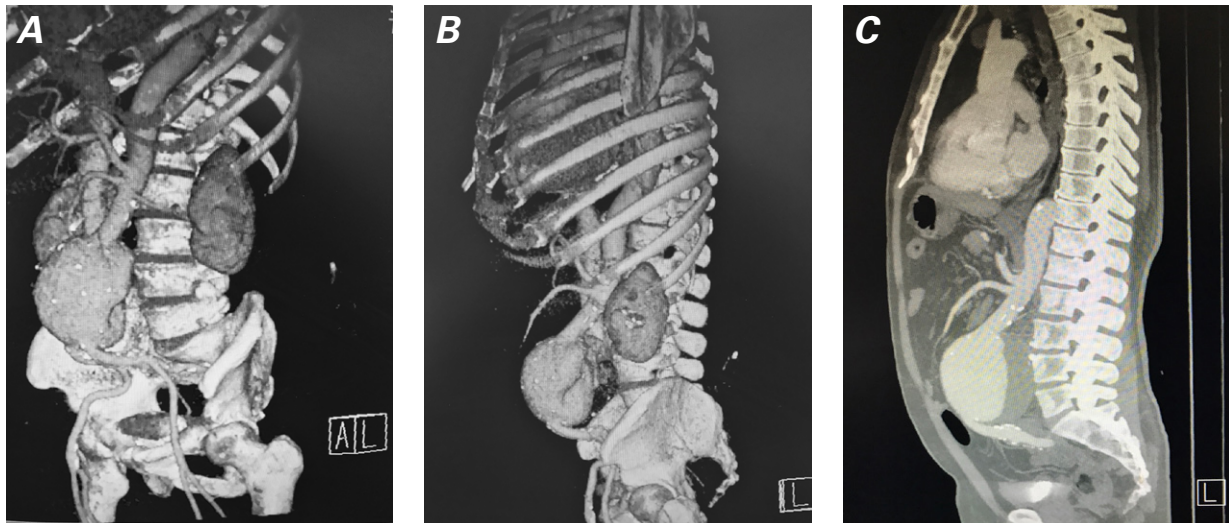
Preoperative abdominal computed tomographic angiograms in A) anterolateral and B) sagittal views show acute angulation between the aorta and common iliac arteries. C) The sagittal view shows acute angulation between the aorta and common iliac arteries.
